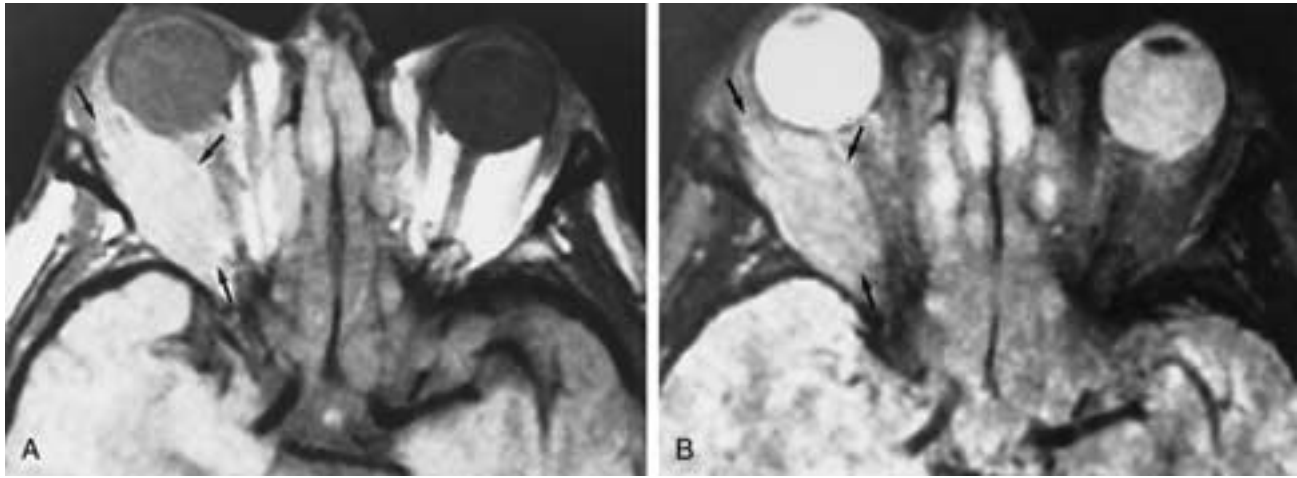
Pseudotumor. A, Axial PW MR image. B, Axial T2-weighted MR image. Scans show infiltrative process (arrows) compatible with pseudotumor. The lesion is isointense to brain on PW and T2-weighted MR scans. (From Curtin HD. Pseudotumor. *Radiol Clin North Am* 1987;25:583.)
